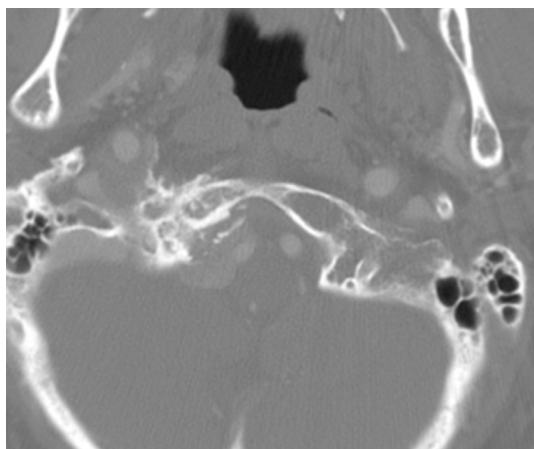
Meningioma causing hypoglossal denervation. Axial-enhanced CT shows a mass surrounding the hypoglossal canal with the characteristic hyperostosis of a meningioma.
